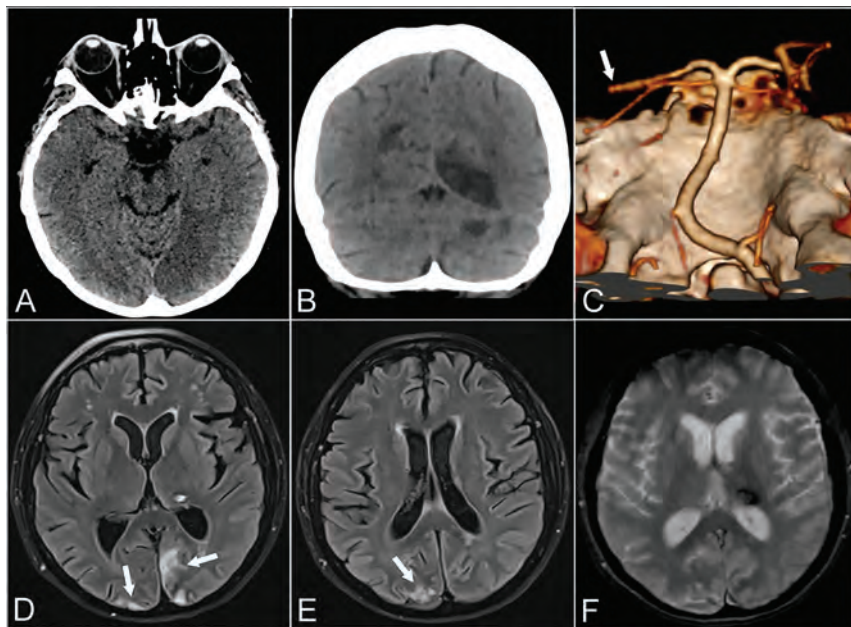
Patient 1. A 57-year-old woman with psychomotor retardation, left gaze deviation, and right superior and inferior limb paresis. Axial CT at baseline shows medial occipital loss of gray-white differentiation consistent with acute ischemia (A). Ten days later, coronal CT shows additional well-defined left cerebellar and right parieto-occipital hypoattenuating areas in keeping with subacute ischemia (B). Left distal posterior cerebral artery occlusion on CTA VR (Volume Rendering) reformats from the same day (white arrow, C). Axial T2 FLAIR (D and E) and axial T2* gradient recalled-echo (F) 6 weeks later show focal left thalamic signal drop-out, consistent with hemorrhage. Early chronic ischemic changes are also noted in the parieto-occipital lobes (white arrows, D and E).
